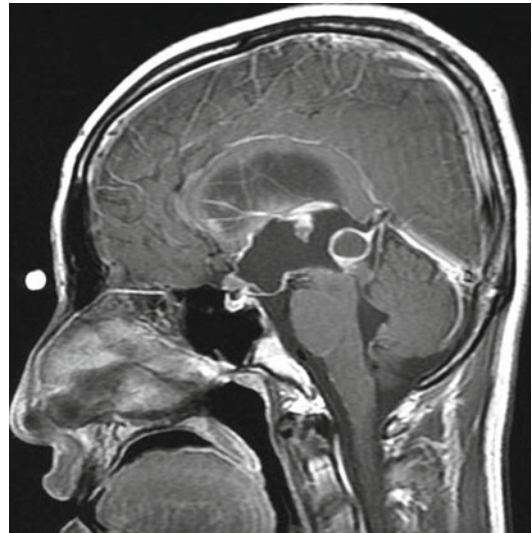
Sagittal T1-weighted MRI after administration of contrast agent reveals a cystic enhancing tumor in the pineal region. This adolescent male who presented with symptoms of hydrocephalus had no detectable serum markers (AFP, HCG) and thus underwent a simultaneous endoscopic third ventriculostomy and tumor biopsy. He was subsequently treated for a pure germinoma with no further surgery
